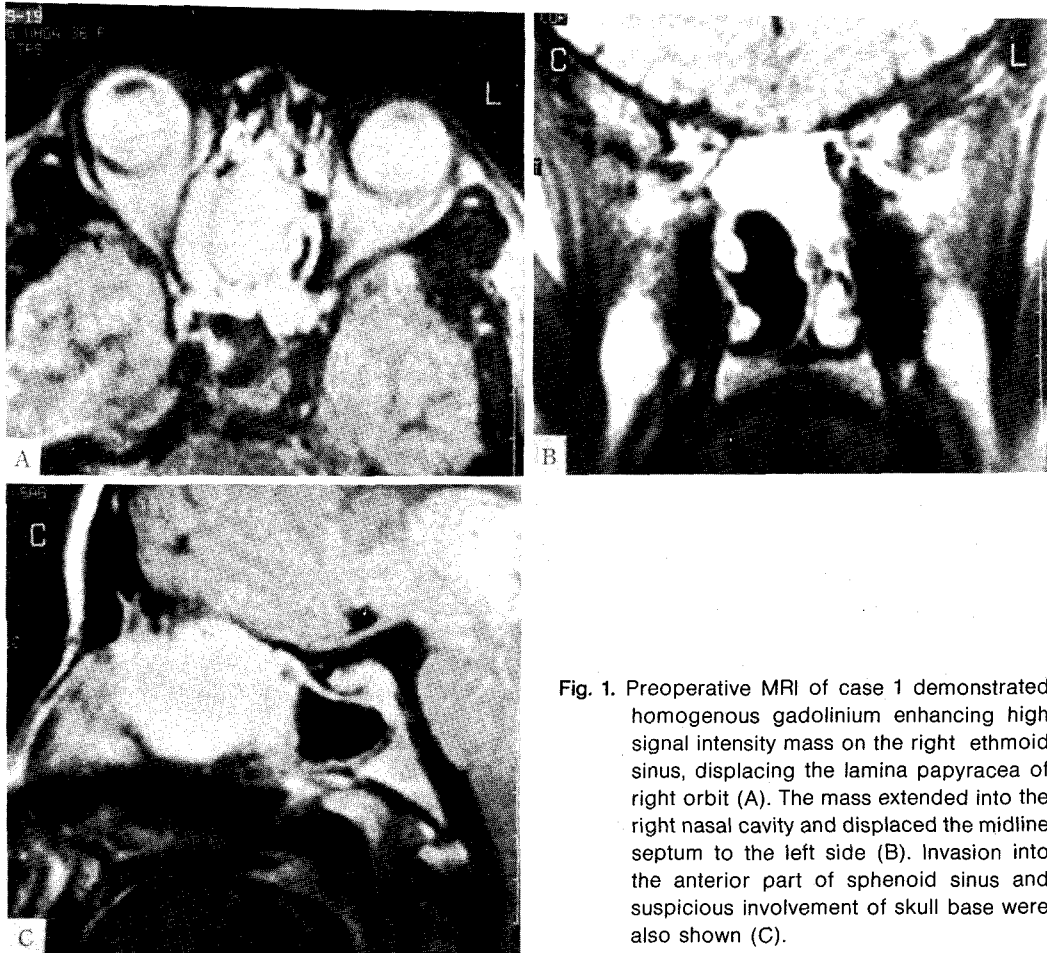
Preoperative MRI of case 1 demonstrated homogenous gadolinium enhancing high signal intensity mass on the right ethmoid sinus, displacing the lamina papyracea of right orbit (A). The mass extended into the right nasal cavity and displaced the midline septum to the left side (B). Invasion into the anterior part of sphenoid sinus and suspicious involvement of skull base were also shown (C).
